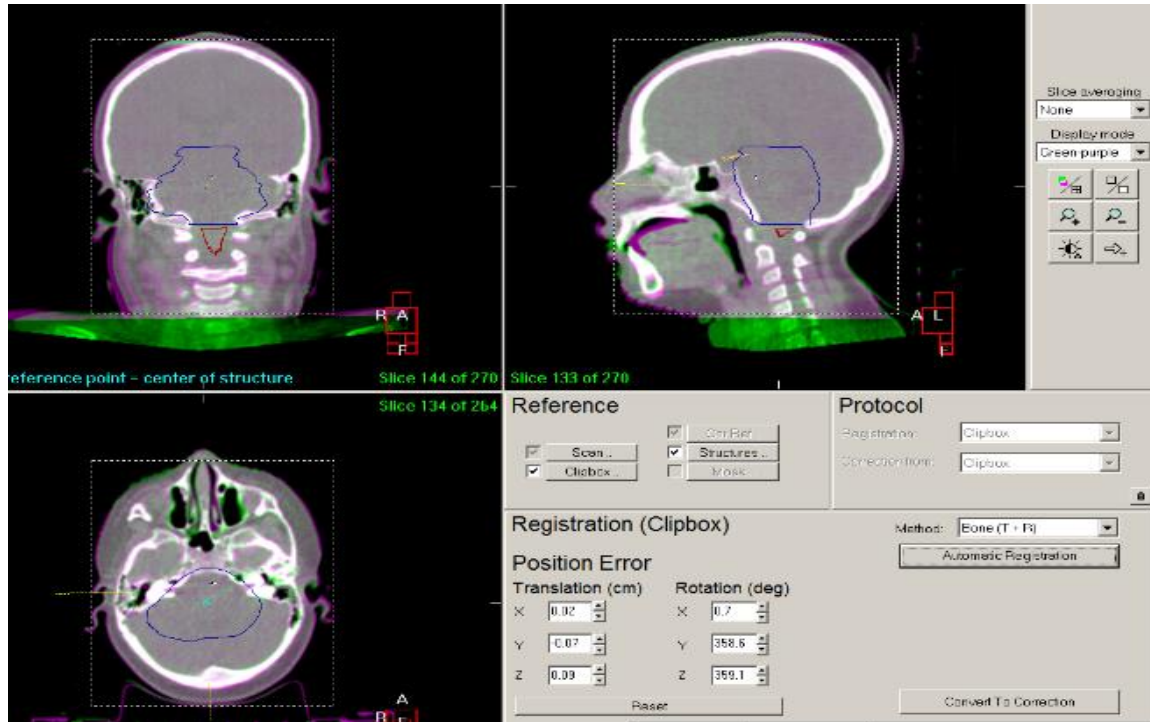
CBCT scan matching registration was done with the reference CT images, and the setup deviations were recorded.
